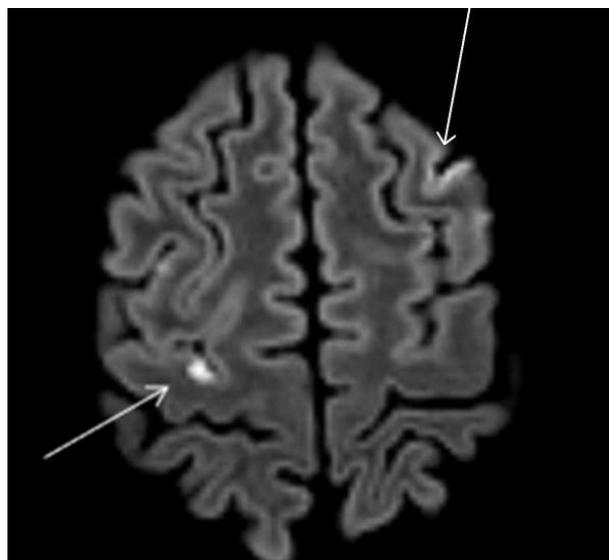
Magnetic Resonance Imaging (MRI) of a cross-section of the brain. The two white arrows show the small subacute cortical and subcortical ischemic punctate lesions.
